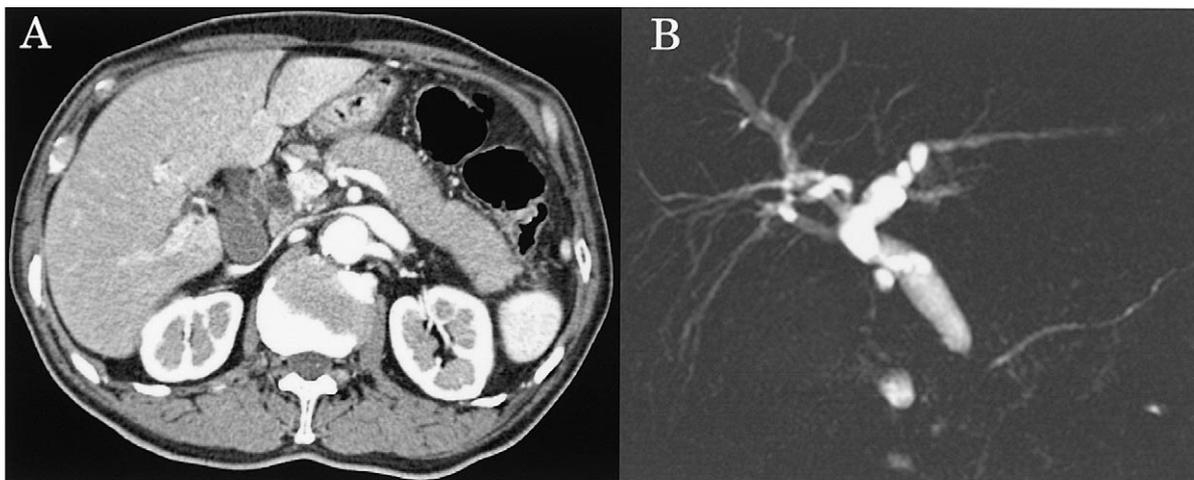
A. Computed tomography (CT) scan shows diffuse enlargement of the pancreas with sharp borders, poorly enhancing on arterial phase with its so called "sausage-like appearance". B. Magnetic resonance cholangiopancreatography (MRCP) shows narrowing of the distal main bile duct with upstream dilatation of the bile duct. The main pancreatic duct is in normal range.
